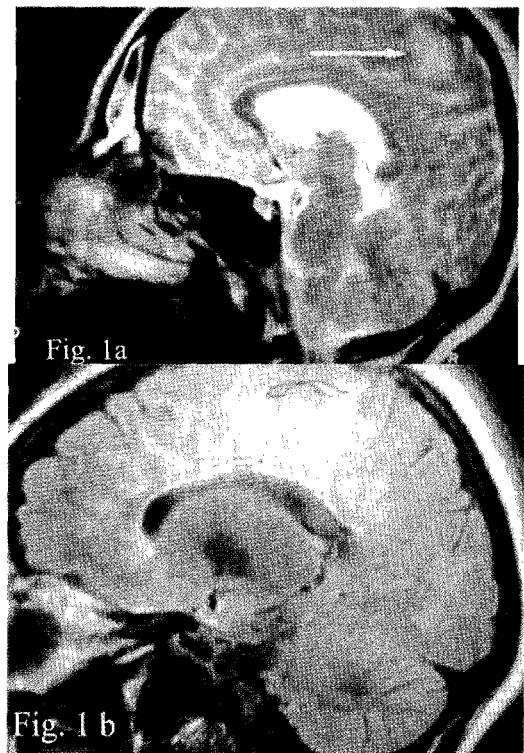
T2W and Fast FLAIR images obtained in 18-year-old woman with MS. a. The T2W images did not show the subcallosal striations, only a big MS plaque was noted (arrow). b. In the FLAIR images, subcallosal, linear, hyperintense lesions perpendicular to the ependyma are noted. They are most prominent in areas adjacent to the body of the lateral ventricles (arrow) the large deep white matter lesions are still noted (curved arrow).
